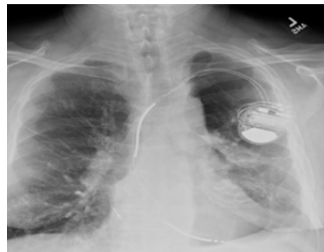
Image Xray: PA Chest x-ray for a 65 year old male, bi-lateral lung transplant.
